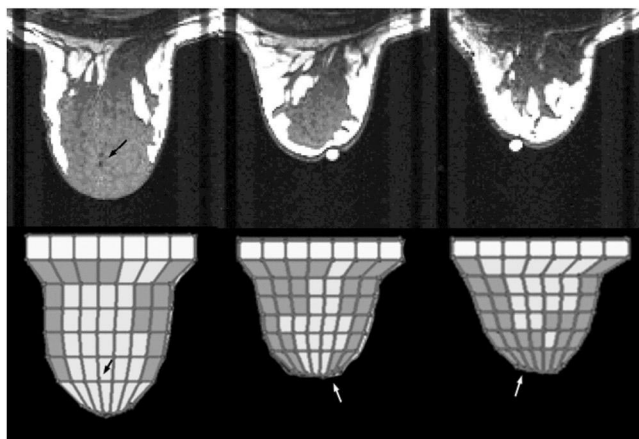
Uncompressed MR images (top), and uncompressed model slices (bottom).
